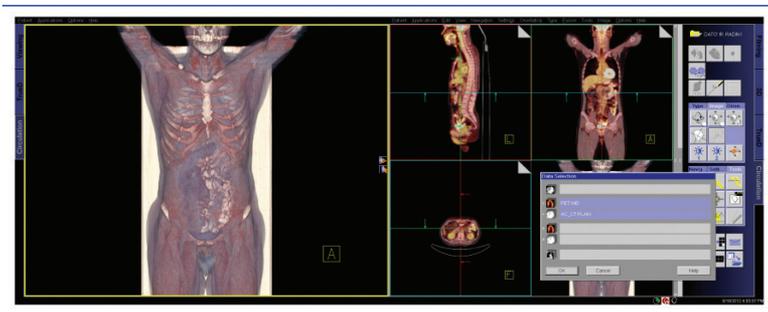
A set of images in multiplanar display will appear on the screen with a new table. Select both studies label 'PT' and 'CT'. Then select 'OK'
